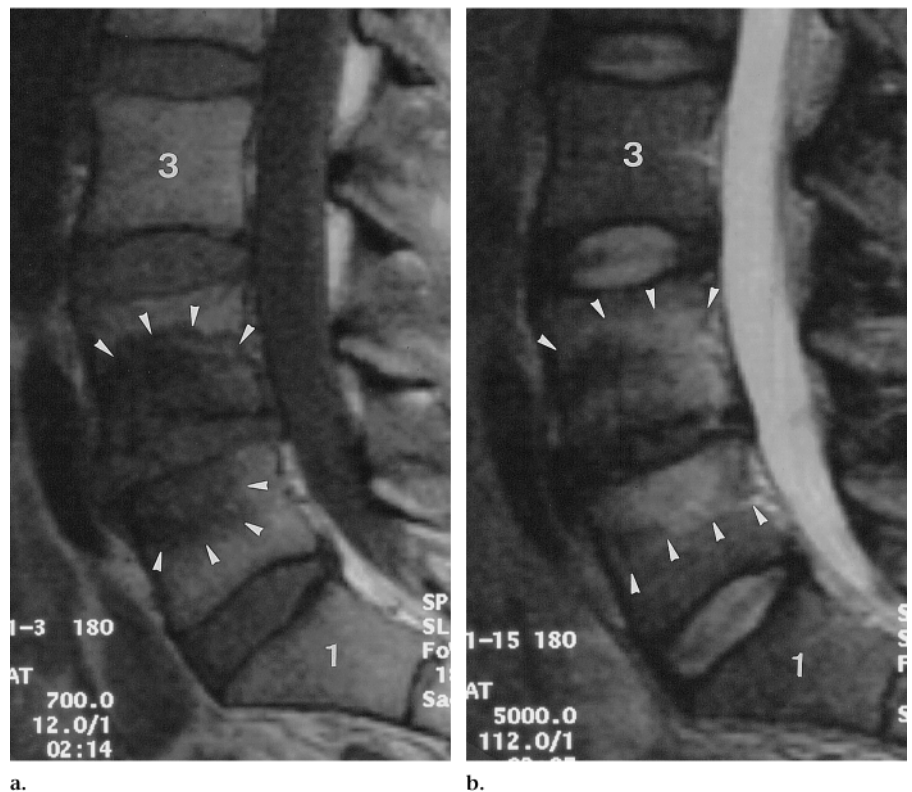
MR images of the lumbar spine in a 35-year-old woman demonstrate the criteria used to identify severe endplate abnormalities. (a) Sagittal T1-weighted (700/12) turbo spin-echo image shows extensive bone marrow abnormalities of low signal intensity (arrowheads) (cranial or caudal extent $\geq 50\%$ of the vertebral height as measured on a midsagittal MR image) adjacent to both endplates at the L4-to-L5 disk intervertebral level. (b) Sagittal T2-weighted (5,000/112) turbo spin-echo image shows an increase in signal intensity (arrowheads) of bone marrow, consistent with a severe type I endplate abnormality. There is grade 4 degeneration of the L4-to-L5 intervertebral disk. 1 = S1 vertebra, 3 = L3 vertebra.
